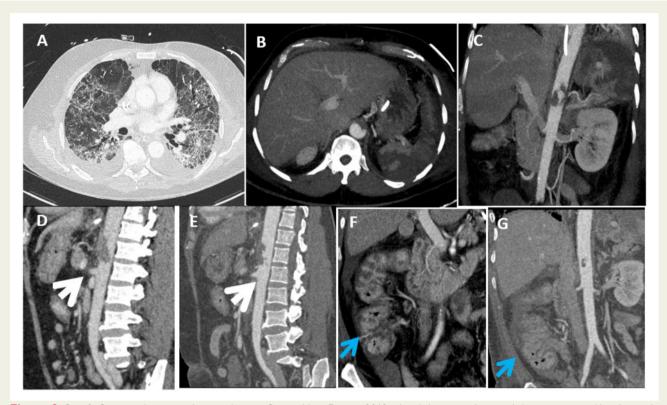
Case 2. Computed tomography scan showing Corona Virus Disease 2019 related changes with ground glass opacities and basal consolidation with small effusions (*A*), abdominal aorta thrombosis and splenic infarcts demonstrated on axial contrast enhanced computed tomography (*B*) and coronal reformat (*C*). Sagittal reformats demonstrate thrombus in abdominal aorta pre-thrombolysis (*D*) and post-thrombolysis (*E*). White arrow points to superior mesenteric artery (SMA) origin. Note reduction in size of thrombus post-fibrinolysis. Coeliac oedema (blue arrow) suggestive of ischaemia pre-thrombolysis (*F*), improved post-thrombolysis (*G*).
